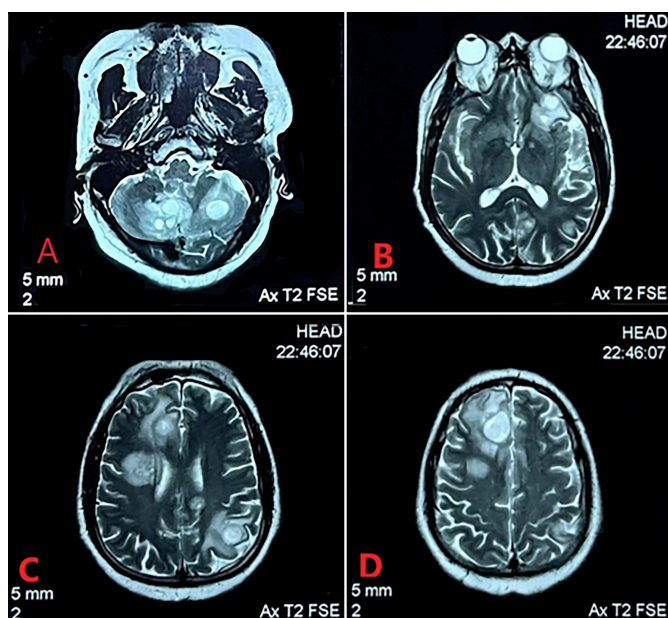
MRI brain axial T2 slices showing hyperintense lesions with surrounding vasogenic oedema in (A) cerebellum, (B) left temporal grey matter, (C) right frontal (parasagittal), parietal and left occipital regions, and (D) right frontal region.
